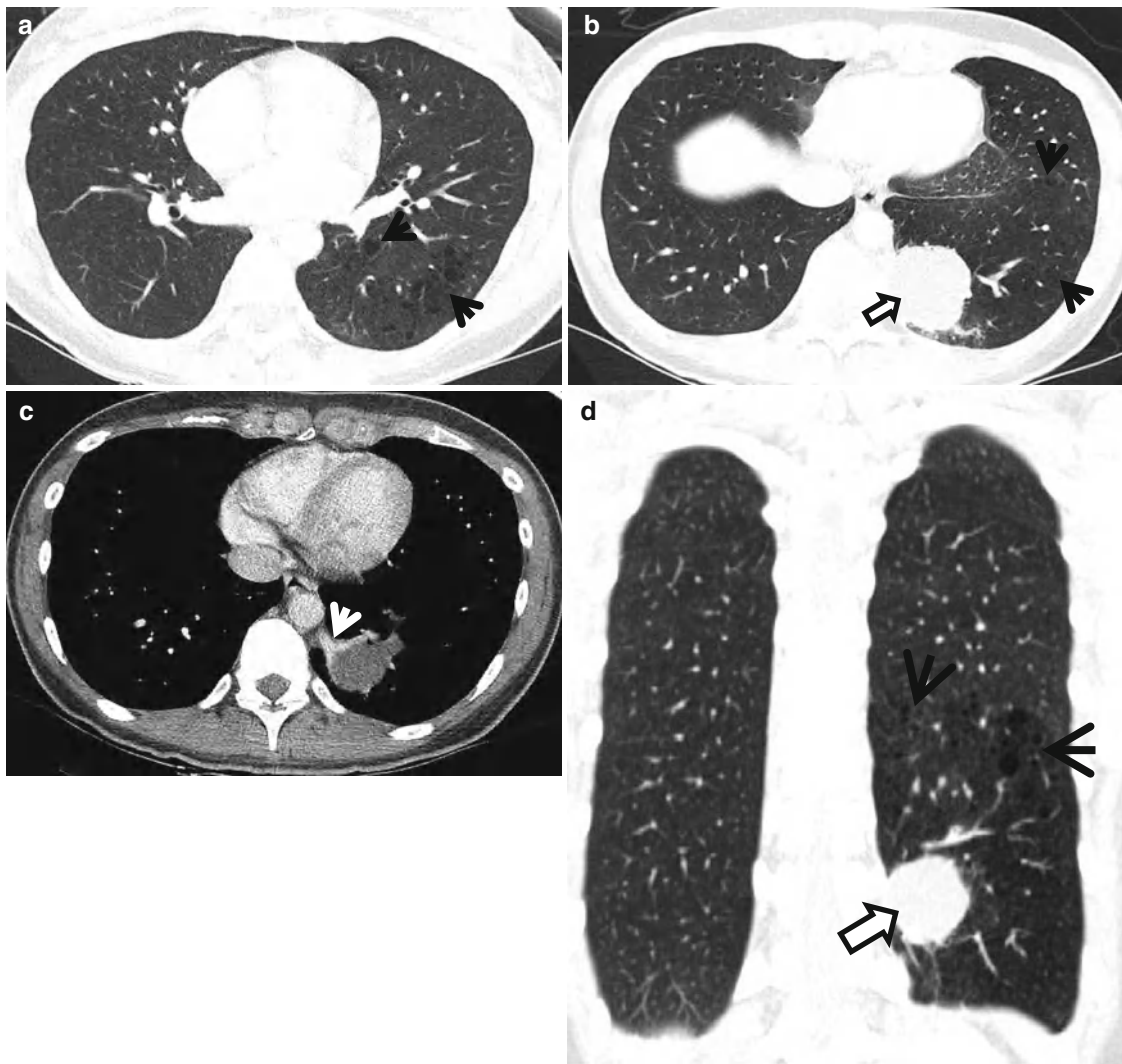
Pulmonary sequestration in a 24-year-old woman. (a, b) Lung window images of CT scans (2.5-mm-section thickness) obtained at levels of inferior pulmonary veins (a) and liver dome (b), respectively, show unusual air-filled cystic aggregation (arrows) and a round soft-tissue mass (open arrows) in left lower lobe. (c) Mediastinal window image
